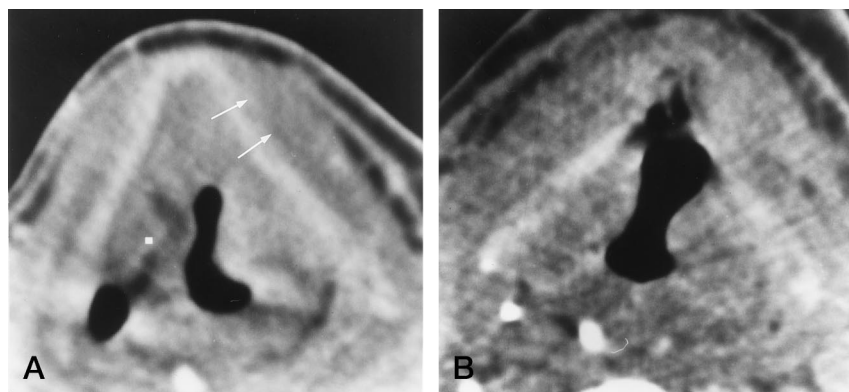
A, Pretreatment CT scan of a patient with a T3 supraglottic carcinoma at the level of the false cords shows tumor massively growing in the preepiglottic space, reaching against thyroid cartilage with subtle thickening of the left prelaryngeal strap muscles (arrows). There is subtle evidence of cartilage invasion.
